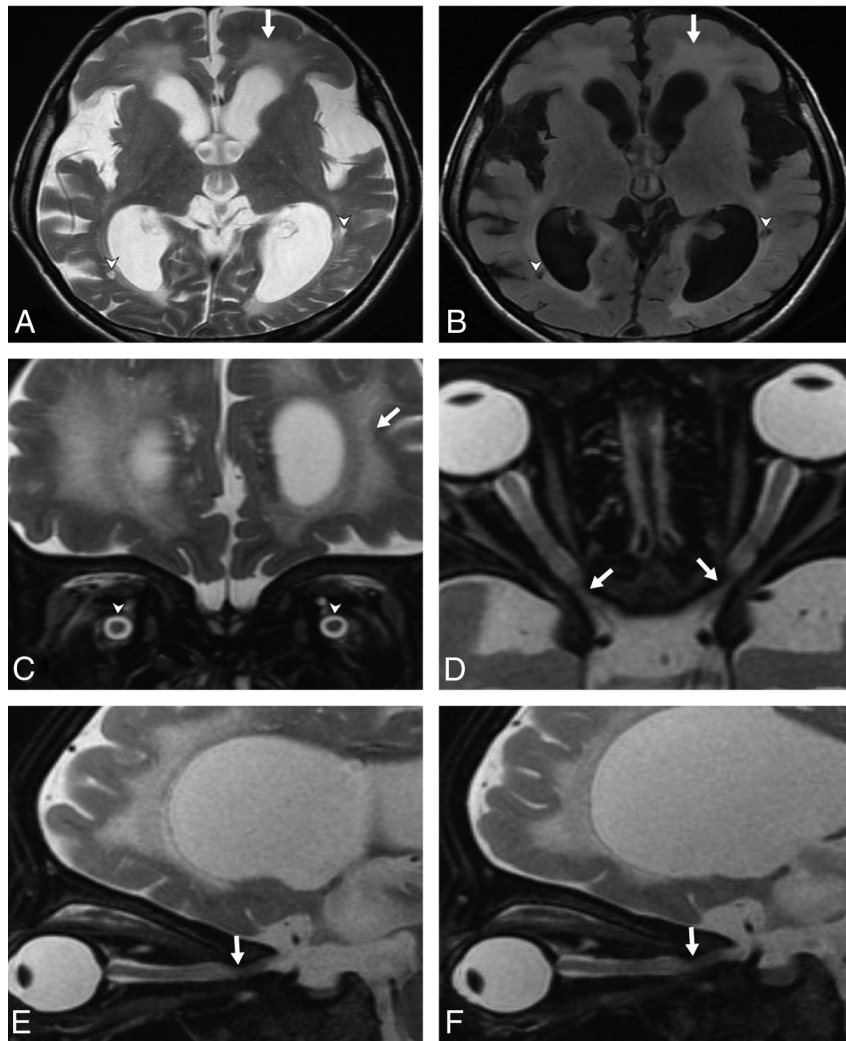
Axial T2 (A) and axial T2 FLAIR (B) images show periventricular white matter hyperintensities (*arrows*), prominent Virchow-Robin spaces (*arrowheads*), ventriculomegaly, and brain atrophy. C, Coronal T2 image shows hyperintensities in periventricular white matter (*arrows*) and perioptic spaces (*arrowheads*), ventriculomegaly, and brain atrophy. Axial T2 (D) and right (E) and left (F) sagittal T2 images show narrowing of the optic canals (*arrows*), hyperintensities in perioptic spaces, and brain atrophy.
